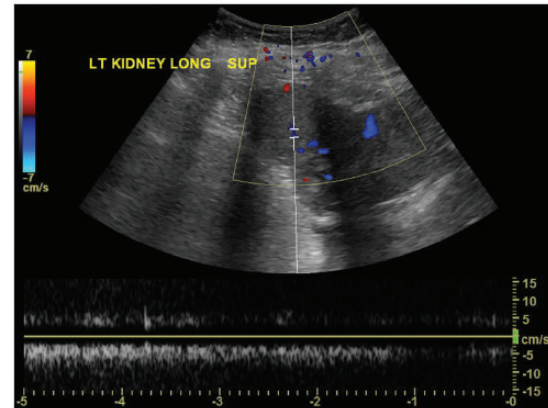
Color and spectral Doppler ultrasound longitudinal image of the mass in the upper pole of the left kidney – internal blood flow is present as demonstrated with a venous waveform on spectral Doppler.
